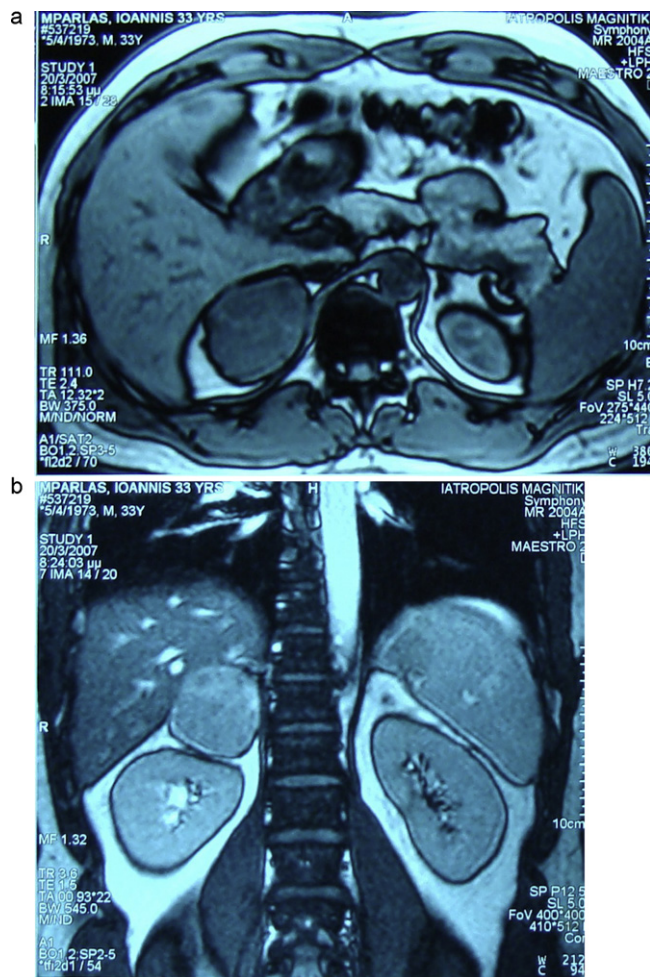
Magnetic resonance imaging right adrenal tumor, measuring 6 cm. The mass has regular margins and a well circumscribed capsule, both of which are characteristics of a benign neoplasia. Note the stones in the right renal pelvis, which initially produced the symptoms of flank pain that led the patient to seek medical assistance. (A) Axial view and (B) sagittal view.
